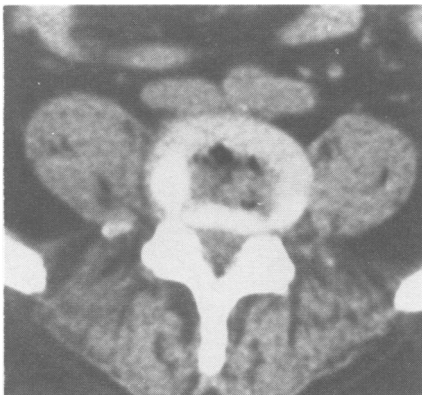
Gas in the L4-5 intervertebral disc space shown by computed tomography.
